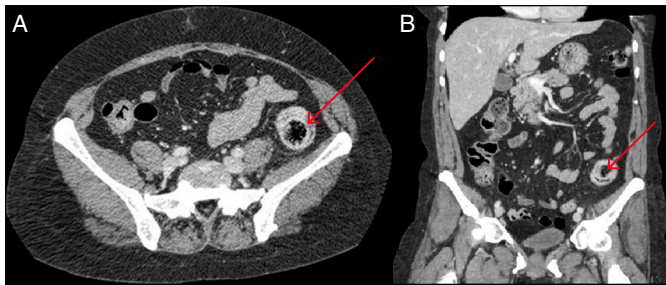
(A) Axial abdominal/pelvic computed tomography (CT) with intravenous contrast depicting 3.5-cm colocolonic intussusception in the descending colon. (B) Frontal abdominal/pelvic CT demonstrating colocolonic intussusception in the descending colon extending over 3.5 cm.
